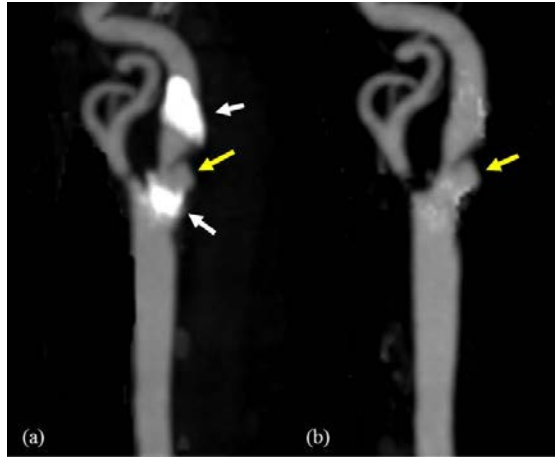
(a) An ulceration (yellow arrow) in a heavily calcified (white arrow) plaque. (b) the ulcer is clearer with calcification removed by dual energy CTA. (The images are processed by the author). With permission [1].
